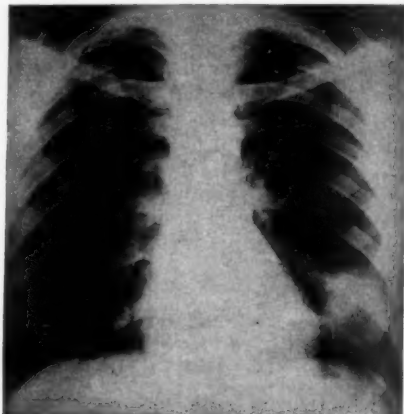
Antero-posterior radiograph of the chest to show the increase in size of the shadow in the lower lobe of the left lung. Taken in August, 1947.
